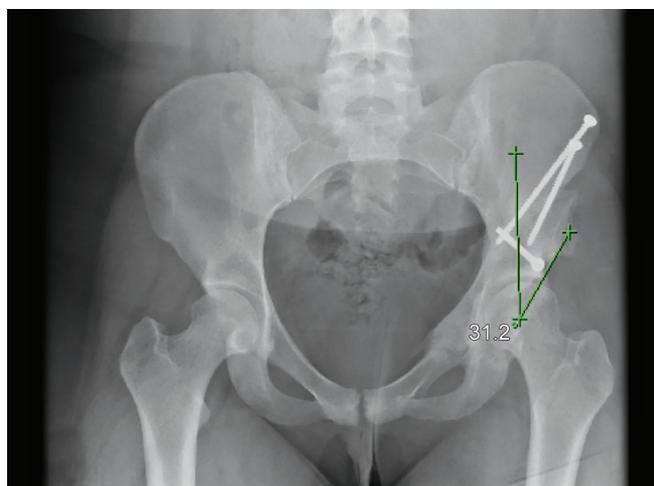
The postoperative weight bearing anteroposterior radiograph after PAO demonstrates correction of the LCEA to 31.2°
